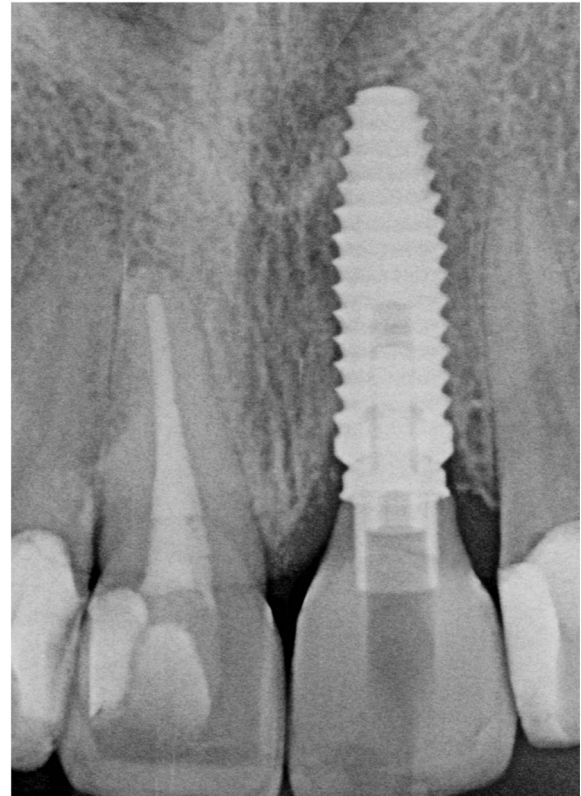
Radiographic view of the emergence profile on a platform-switched implant with a slim and straight C zone
